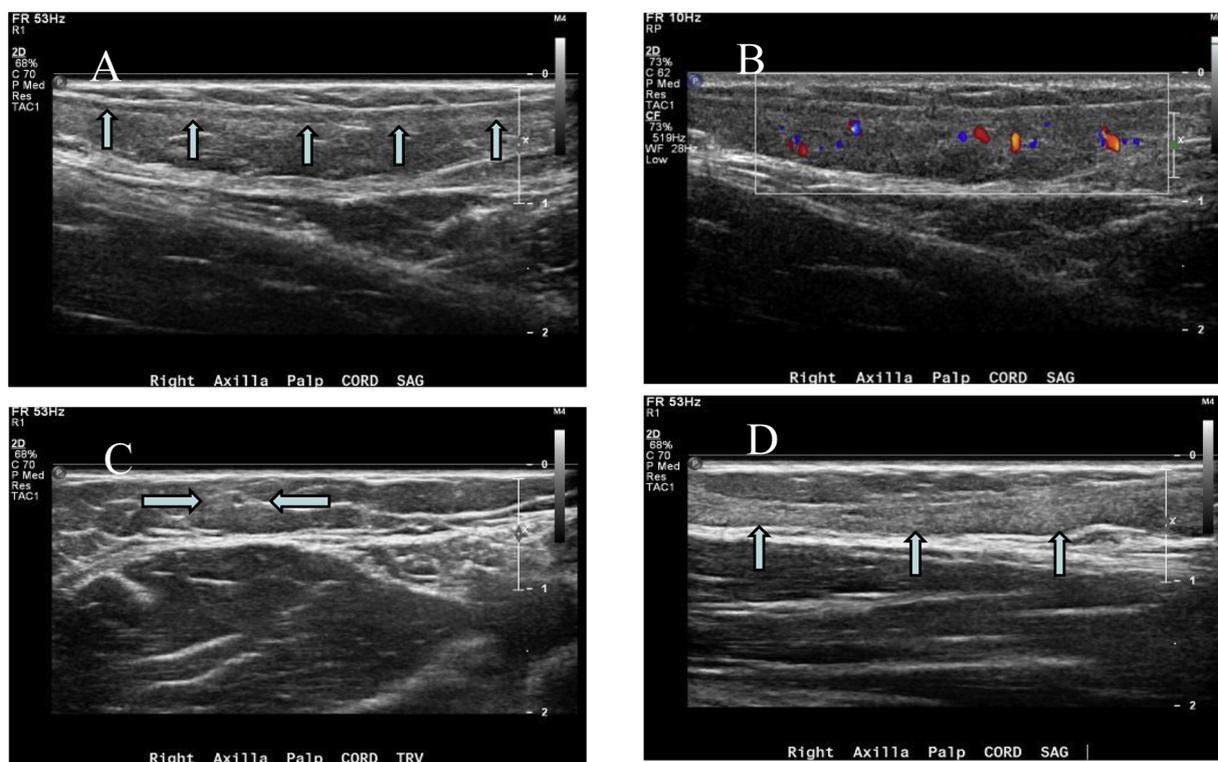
43-year-old woman one week after core needle biopsy of right breast cancer and a right axillary lymph node, presents with a palpable cord in the right axilla, arm pain and limited shoulder abduction. A: sagittal ultrasound image of palpable right axillary cord, B: color Doppler image of the cord showing no flow, C: transverse view of cord, D: increased echogenicity in surrounding subcutaneous fat.
